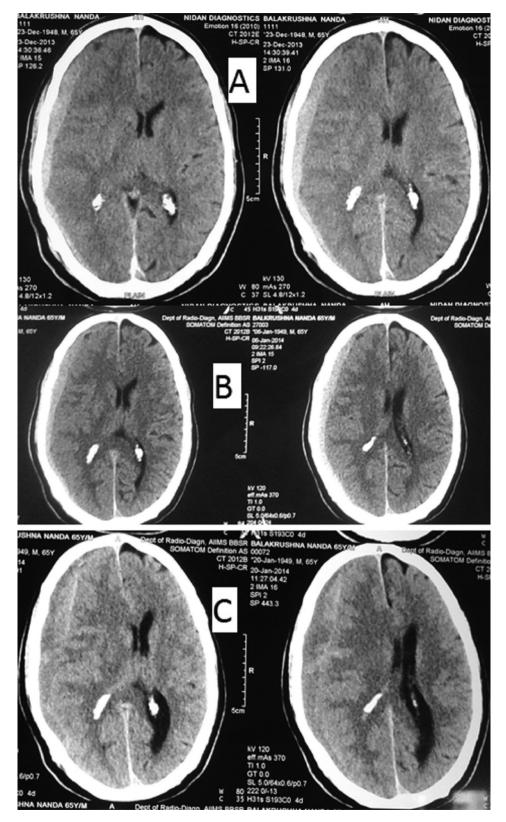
A- Initial CT scan demonstrating a thin acute SDH with minimal midline shift. B – CT scan after 15 days with reduction in hyperdensity. C – Isodense to hypodense collection with gross midline shift and mass effect.
